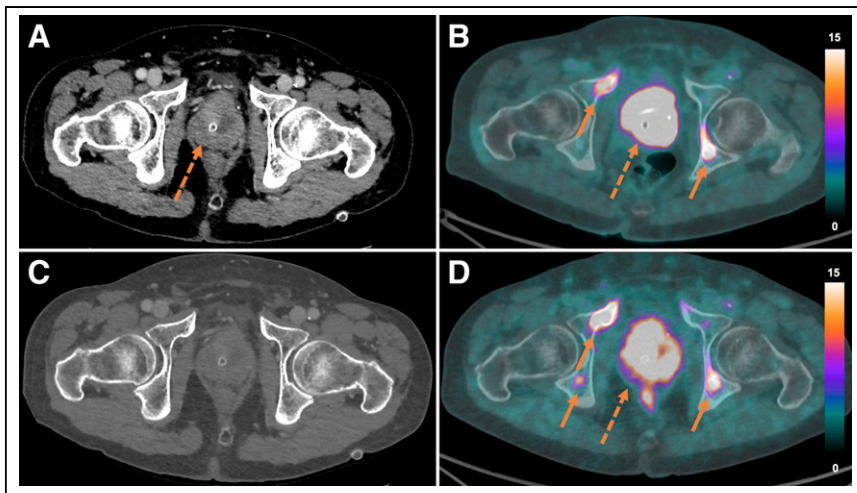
Comparison of ceCT (A and C), ^{18}F -FDG PET/CT (B), and $^{64}\text{CuCl}_2$ PET/CT (D). On ^{18}F -FDG PET/CT, 2 localizations were seen in pelvic bones (solid arrows); bladder wall (dashed arrow) could not be evaluated because of urinary ^{18}F -FDG activity. On $^{64}\text{CuCl}_2$ PET/CT, diffuse uptake in bladder walls was noted (dashed arrow), and additional skeletal localization was disclosed (solid arrows). No bone localization was detected on ceCT. Uptake intensity is expressed in SUV.
